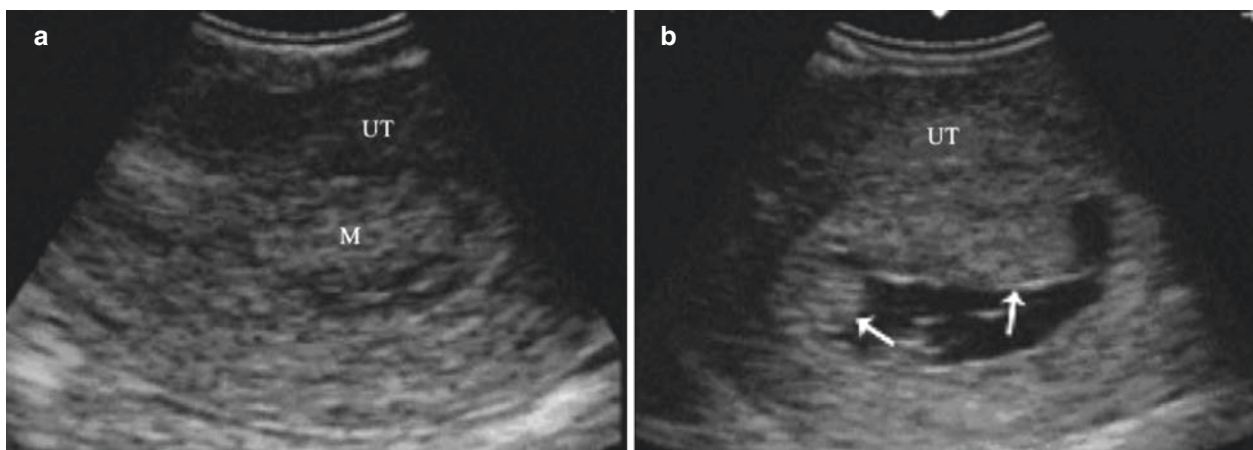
Sonohysterography of multiple endometrial polyps (II). (a) The patient is 34 years old, and the ultrasound found “occupation disease in uterine cavity”. (b) After injection of the contrast agent, multiple slightly hyperechoic masses are found in each wall of the uterine
